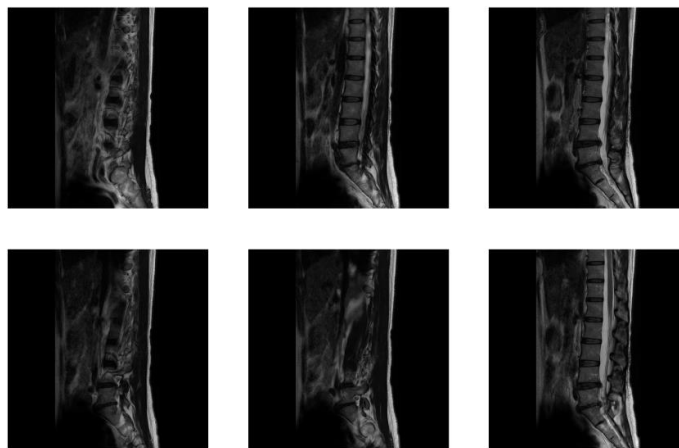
Input Large CT scan images.
